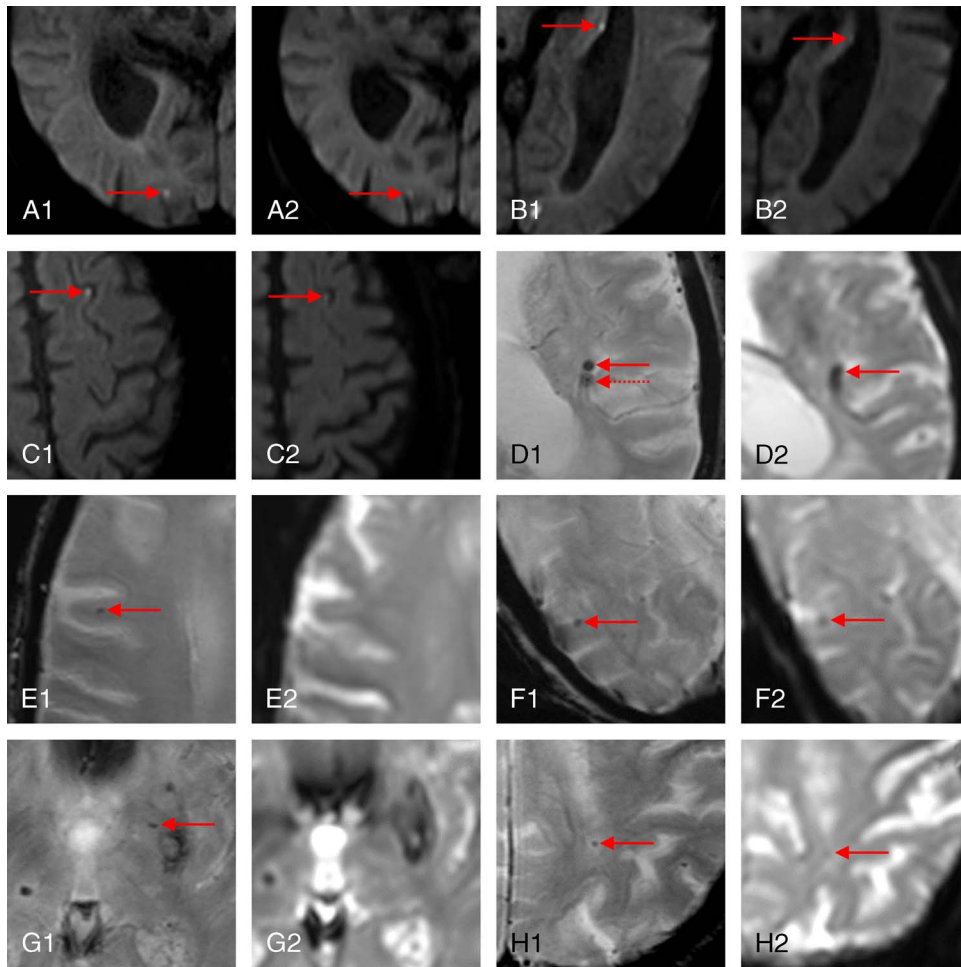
Additional lesions in the standard-length protocol compared with ultrafast-MRI. Eight additional lesions (ischemia, $n = 3$; hemorrhage/microbleeds, $n = 5$) were detected in the standard-length protocol. A1, B1, C1, DWI/standard-length protocol. A2, B2, C2, DWI/ultrafast-MRI: small focal diffusion restrictions (A, right occipital lobe; B, left hippocampus; C, left superior frontal gyrus) were visible on both the standard-length and ultrafast-MRI. However, due to low signal intensity on ultrafast-MRI, they were only judged as acute ischemia based on the standard-length sequence. D1, E1, F1, G1, H1, T2*/standard-length protocol. D2, E2, F2, G2, H2, T2*/ultrafast-MRI: 3 microbleeds (E, right frontal lobe; F, right occipital lobe; H, left parietal lobe) demonstrated low susceptibility on ultrafast-MRI and were therefore only read in the standard-length protocol. Due to lower resolution, 2 adjacent microbleeds (D, left insula) were read as one on ultrafast-MRI. One microbleed (G, left putamen) was not visible on ultrafast-MRI due to low resolution as well as preexisting hemosiderin deposits in the left basal ganglia.
